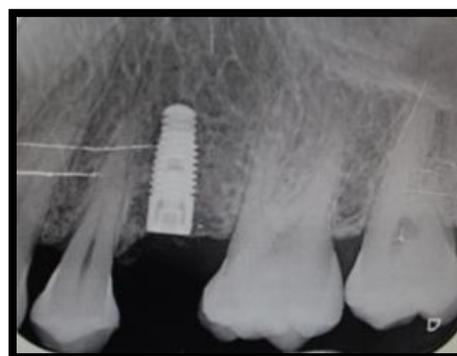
A PA X-ray shows the implant position
